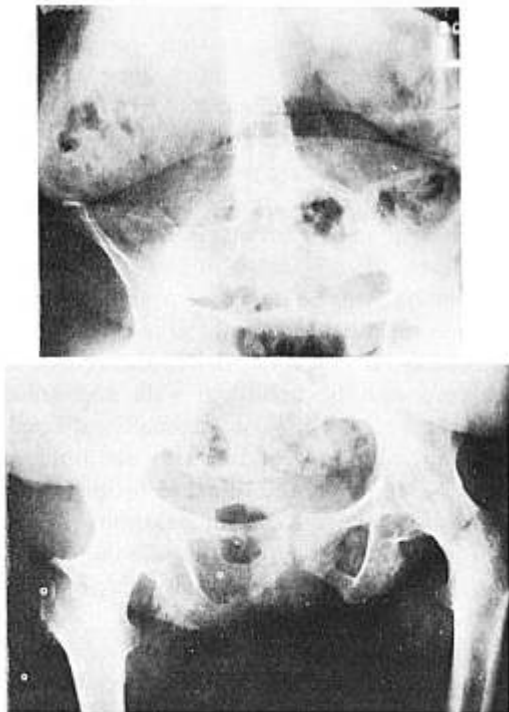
Anteroposterior radiographs showing ankylosis of spine (top) and hip joints (bottom).
